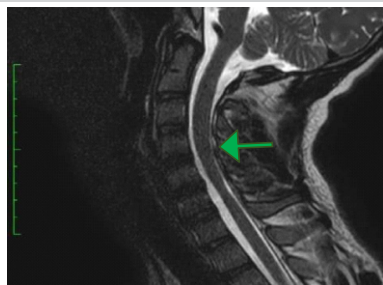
T2-weighted sagittal MRI of cervical spine in extension shows complete disappearance (green arrow) of the crescent shaped mass as the neck is moved from flexion to extension position.
